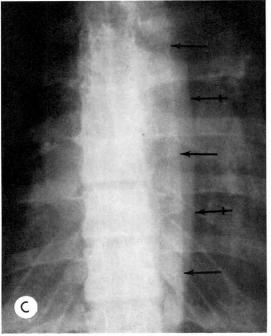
Case III. (A) A supine anteroposterior overexposed grid roentgenogram of February 23, 1964 demonstrating a normal to slightly widened left paravertebral line  $(\leftarrow)$ . (B) A supine anteroposterior overexposed grid roentgenogram of March 16, 1964 demonstrating widening of the left paravertebral line  $(\leftarrow)$  which has obliterated the aortic line  $(\leftarrow)$ . This is compatible with increasing left free pleural effusion. (C) A supine anteroposterior overexposed grid roentgenogram of April 17, 1964 showing return of the left paravertebral line (←) and a ortic line  $(\leftarrow)$  to the pre-effusion state. Roentgenogram taken following thoracentesis.
